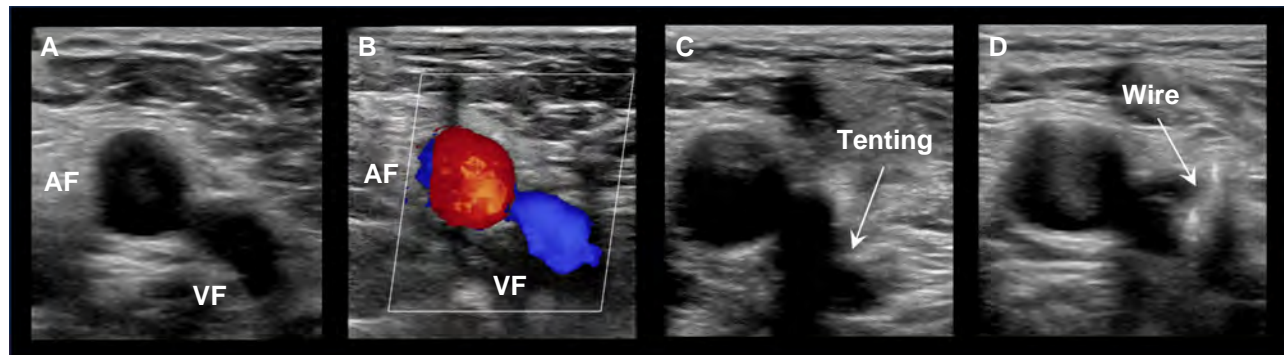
Ultrasound-guided femoral venous access. A: 2D ultrasound short-axis view showing the femoral artery located lateral to the femoral vein. B: Colour-doppler short axis view showing the femoral artery (red, lateral) and femoral vein (blue, medial). C: Tenting of the needle in the femoral vein. D: The wire has been introduced through the needle into the femoral vein. AF: femoral artery, VF: femoral vein.
